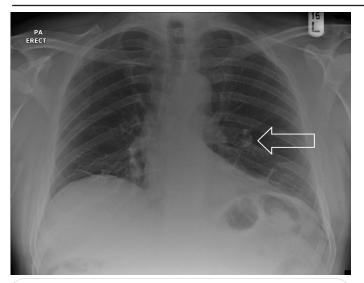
A well defined left mid zone nodule is seen on initial chest radiograph (Arrow).
